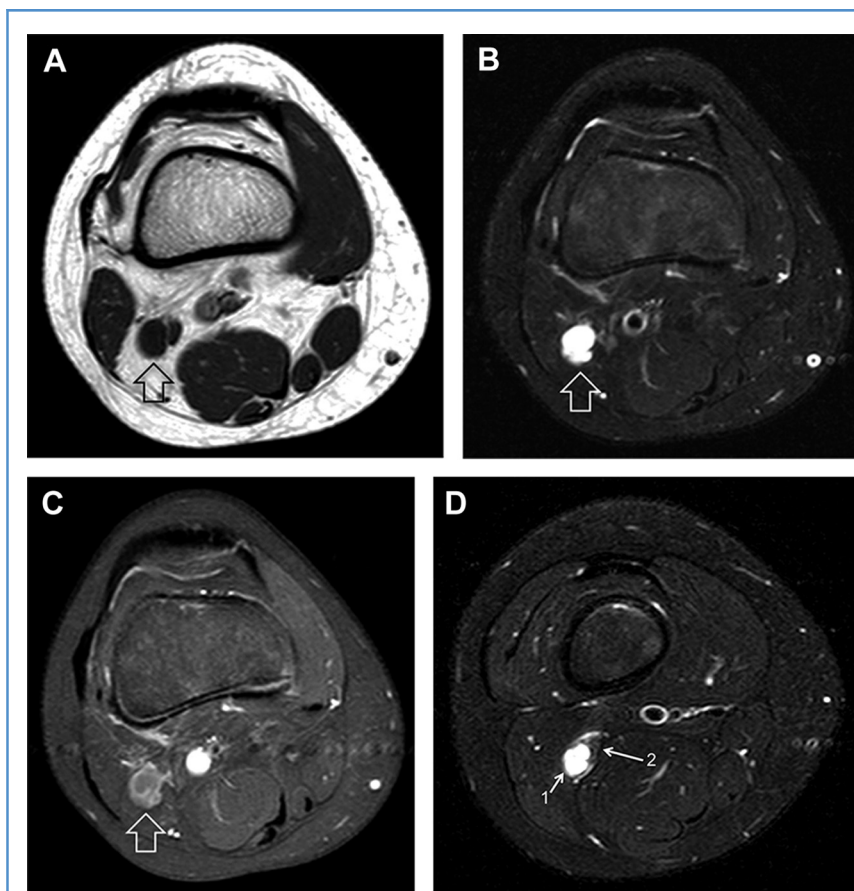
Preoperative magnetic resonance imaging (MRI) examination of the right knee using (A) T1-weighted, (B) fat-suppressed T2-weighted, and (C) gadolinium-enhanced T1-weighted sequences. They demonstrate a swollen, fluid-filled common peroneal nerve (arrow) reflecting intraneural involvement by a large ganglion cyst that expands cranially within the nerve substance from the level of the superior tibiofibular joint. Transverse, fat-suppressed tSE-T2w MRI of the distal thigh (D) reveals the intraneural ganglion of the peroneal nerve reaching the sciatic bifurcation. The cyst (1) entered the sciatic tracking the fascicles of the peroneal nerve. The tibial nerve and tibial component (2) of the sciatic bifurcation were totally unaffected. The longitudinal extension of the cyst in the sciatic was approximately 8 cm without cross-over paths.
